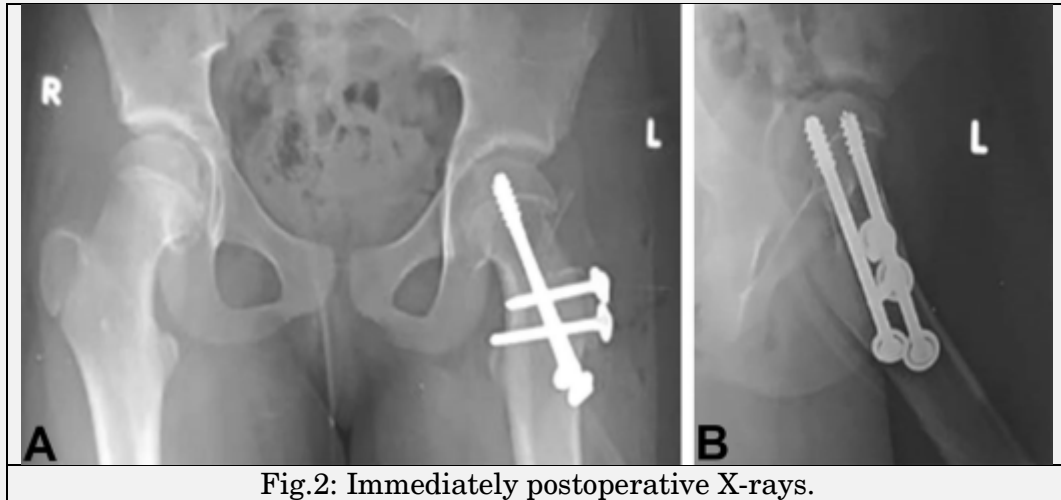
Immediately postoperative X-rays.
